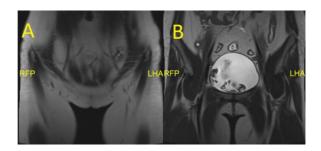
MRI examination results in patients with MRKHS. (A) Left ectopic ovary is found. (B) There is a right ectopic ovary.
